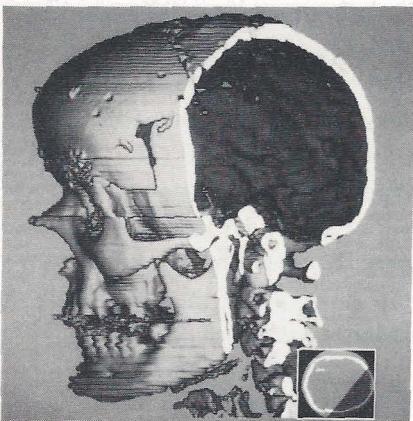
Surface images. Left: Bone surface of a skull with an oblique cut (CT, case 1). Right: Skin surface of a head (MRI, case 2).
